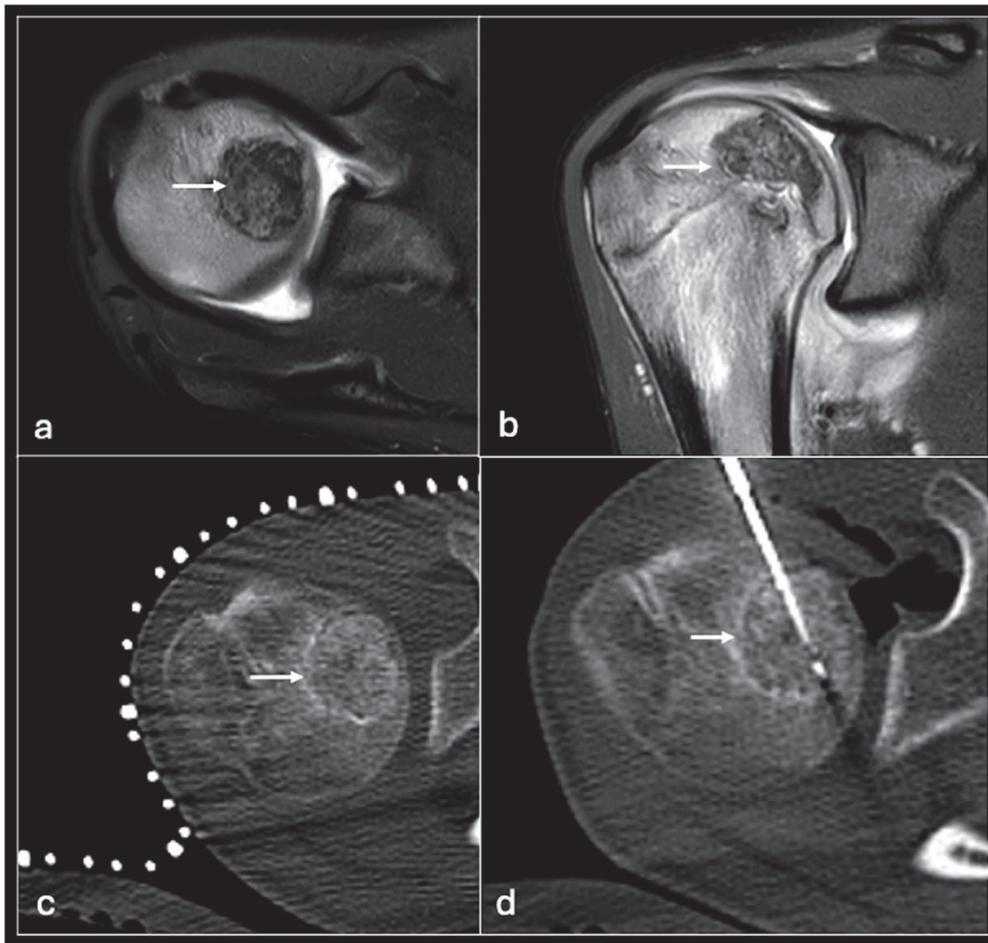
STIR axial (a), coronal (b) showing chondroblastoma in the humeral head (arrow) treated with CT-guided cryotherapy (c,d).
